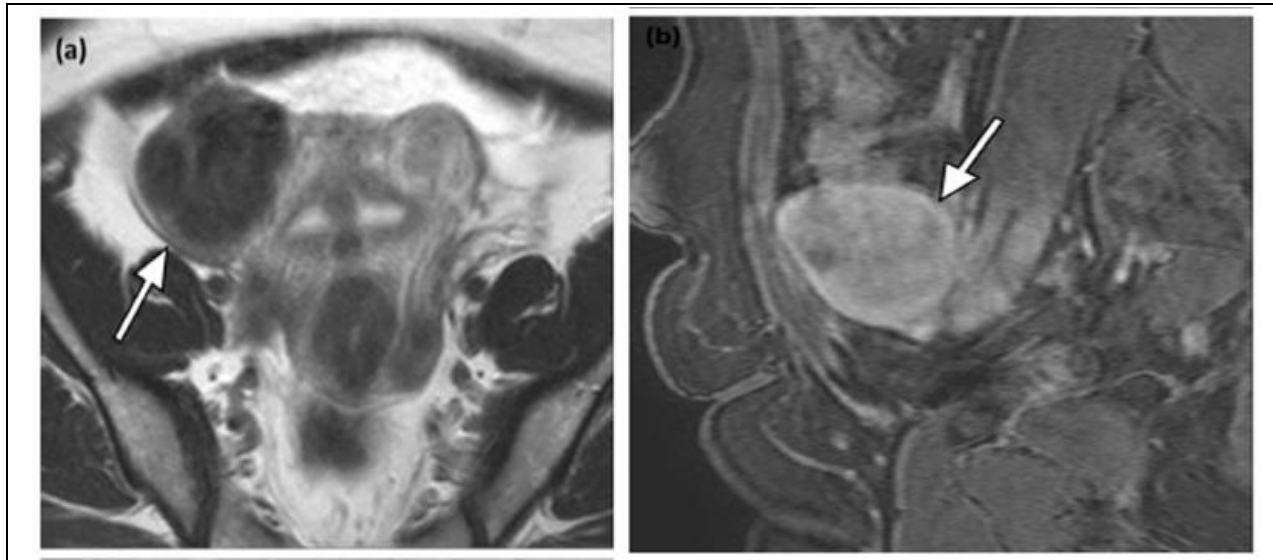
leiomyosarcoma has been misdiagnosed in a 46-year-old lady. The majority of readers seem to think it's a leiomyoma (mean suspicion score: 1.5). a) The arrow in the magnetic resonance (MR) picture of the right uterine (T2-weighted short axis) shows a mass with low signal intensity and signal weakness. Fundus, and in, b) (sagittal, T1-weighted, fat-suppressed, postcontrast); the arrow that indicates the growing uterine size
